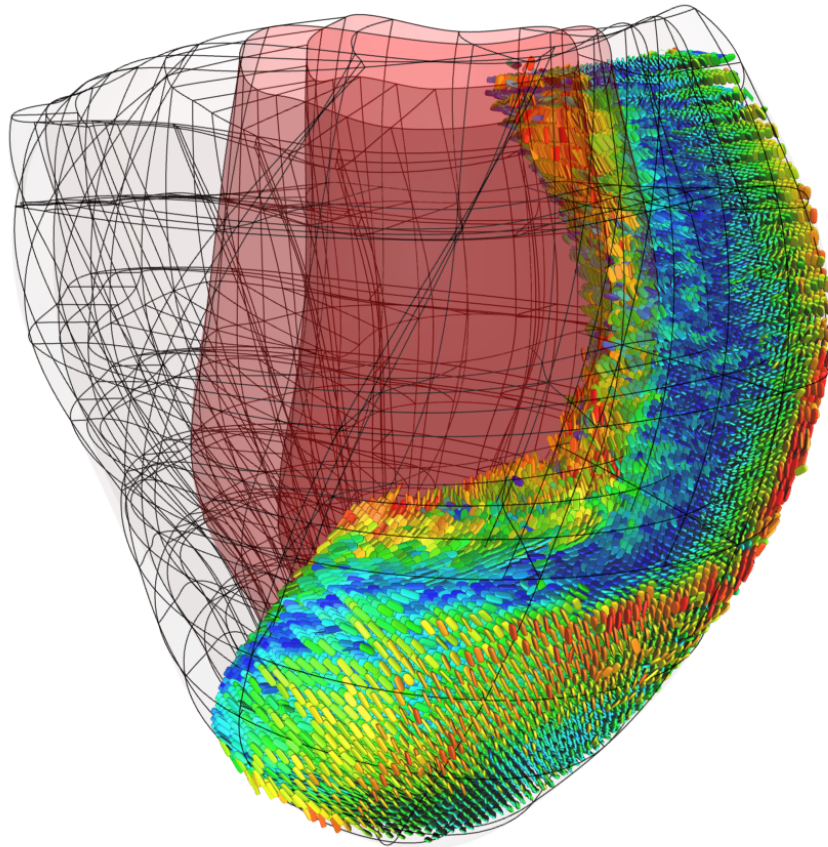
Spatial alignment of DT-MRI data with mesh. This example shows a cut view of a lateral section of diffusion tensors in the LV free wall. The characteristic variation of fiber orientation is evident.
